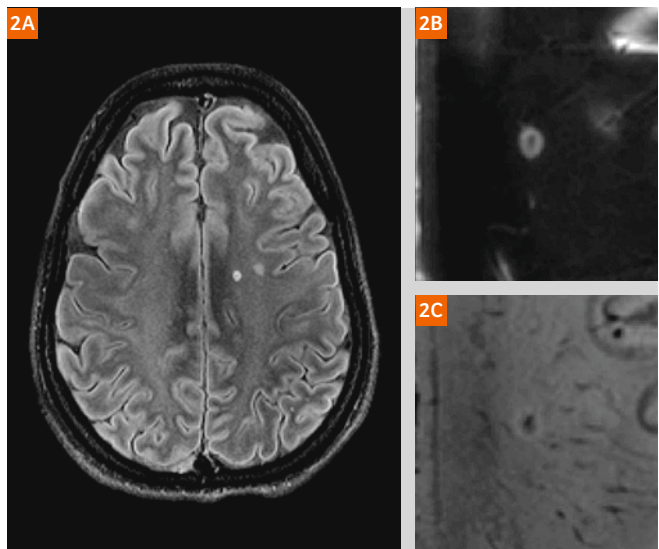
(2A) 7T axial FLAIR (2D TSE) shows hyperintense MS lesion with hypointense center. (2B) Corresponding T2w TSE. (2C) High-resolution SWI shows typical central vein and perivenular demyelination.
